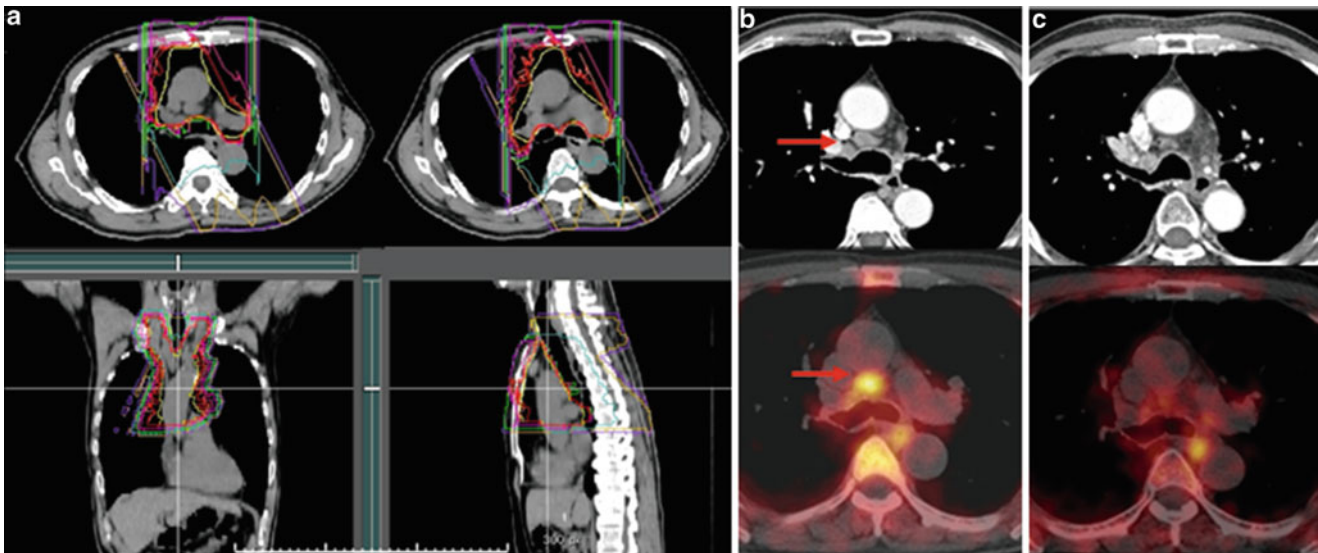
(a) The planning CT for the treatment of the mediastinal and hilar lymph node metastases. (b) The arrow shows the lymph node metastasis. (c) CT and PET images 3 months after CIRT
